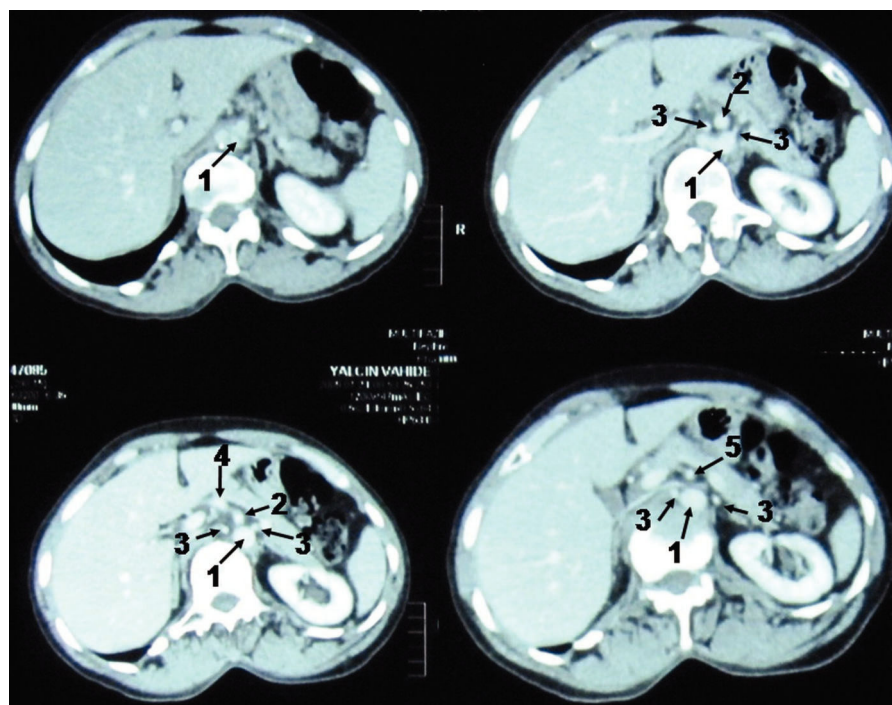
Axial computed tomography (CT) images. 1 = tortuosity; 2 = common celiacomesenteric trunk; 3 = right and left renal arteries; 4 = common hepatic and splenic artery; 5 = superior mesenteric artery.
